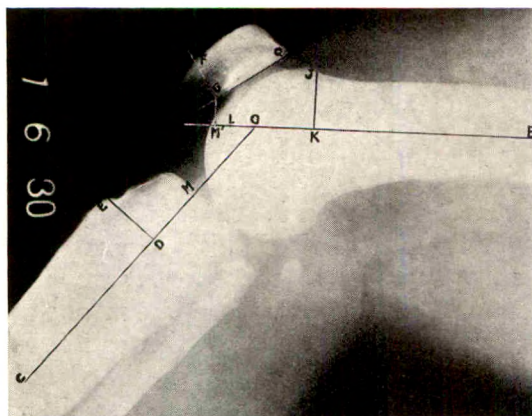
Showing the method of approach and the measurements on a roentgenogram of a normal knee.
